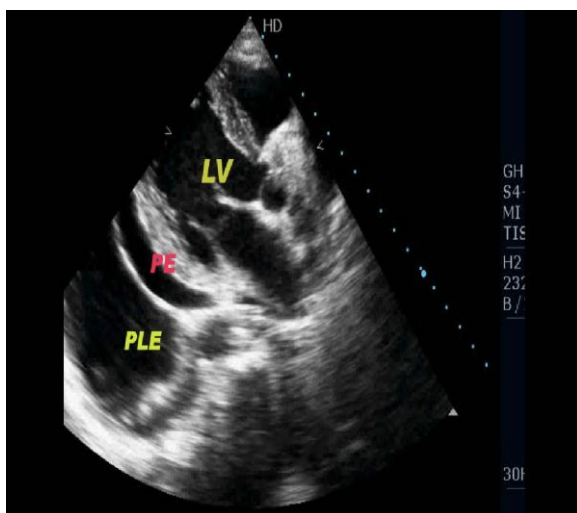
Echocardiography and Ultrasonography revealed mild plural effusion, ascitis and pericardial effusion.
